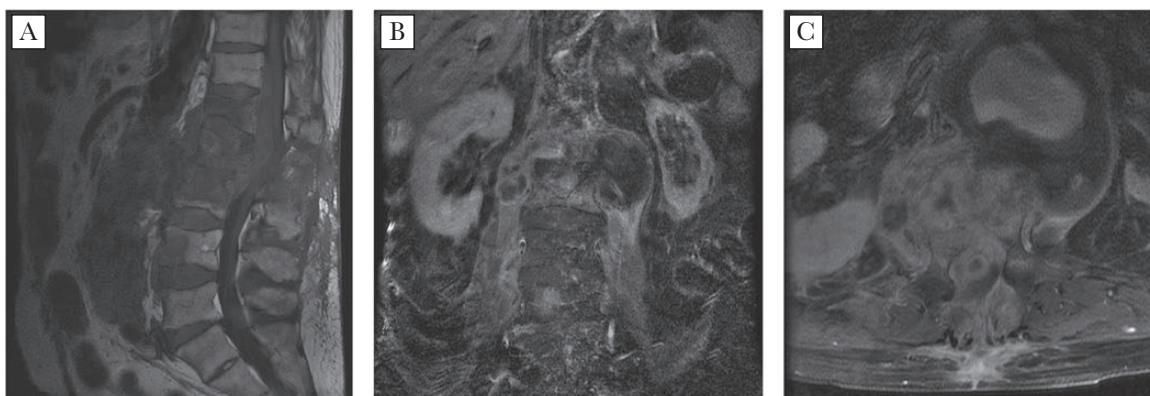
Thoracolumbar spine MRI with diffuse enhancement of L1-L3, epidural abscess extending from T11 to L3, L2 fracture, paraspinal soft tissue and psoas muscles thickening and enhancement, and right psoas muscle abscess. Images: (A) sagittal T2, (B) sagittal T1, and (C) axial.
